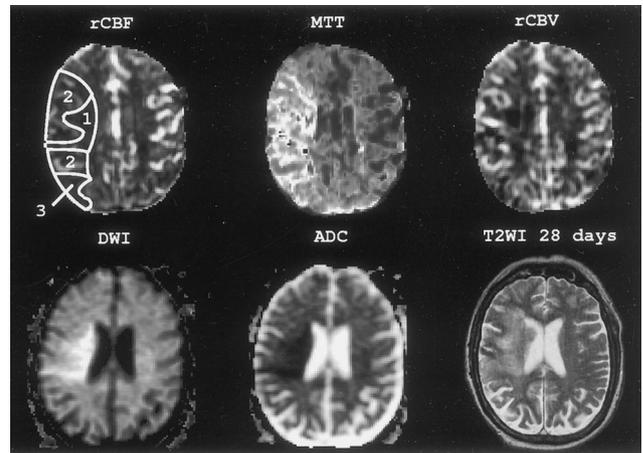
Acute (4-hour) and chronic (28-day) MRI of a 56-year-old man who presented with left hemiparesis, facial paresis, and gaze palsy. Three ROIs were placed manually at the rCBF map (top left): ROI 1 covered the ischemic core as detected from the DWI (bottom left), ROI 2 covered the penumbra that progressed to infarction at the final T2-weighted image (T2WI, bottom right), and ROI 3 covered the penumbra that recovered. Maps of MTT (top middle) showed prolonged MTT in the total right middle cerebral artery territory, whereas rCBV (top right) was markedly reduced in the internal capsule but only mildly reduced in the rest of the middle cerebral artery territory. The ADC map (bottom middle) demonstrates severely reduced ADC in the core of the infarction.
